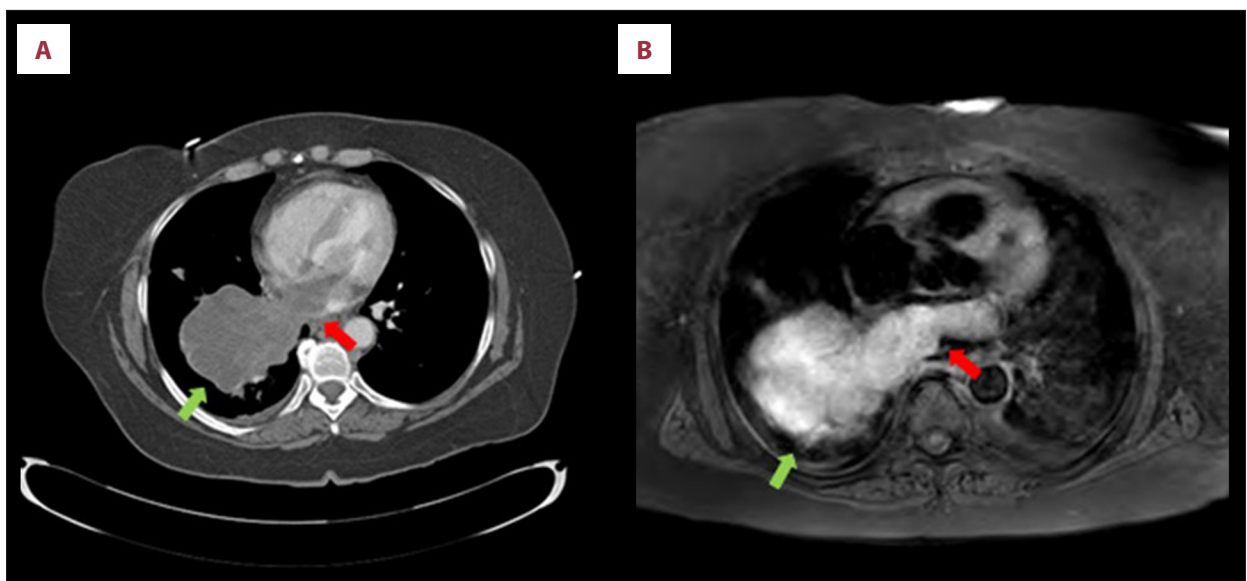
CT scan (A) and MRI (B) of the chest showing a pulmonary vein and left atrial tumor invasion (red arrows) and right lower lobe primary tumor (green arrows).
